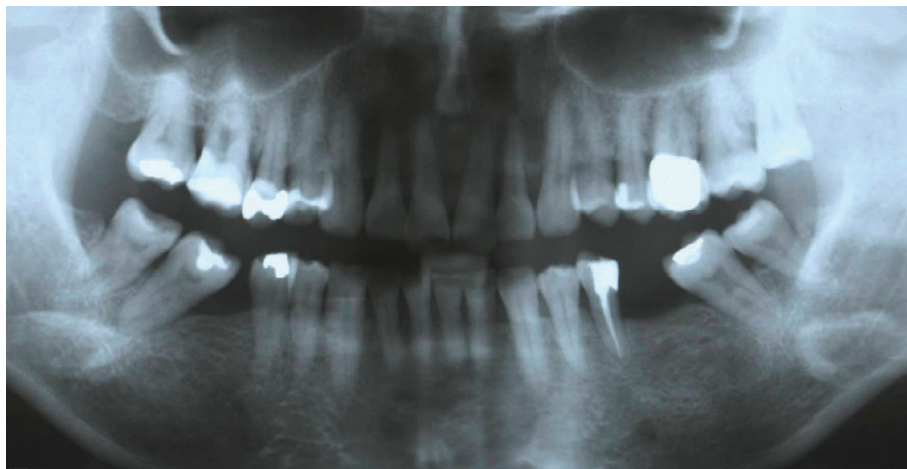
Orthopantomogram.
